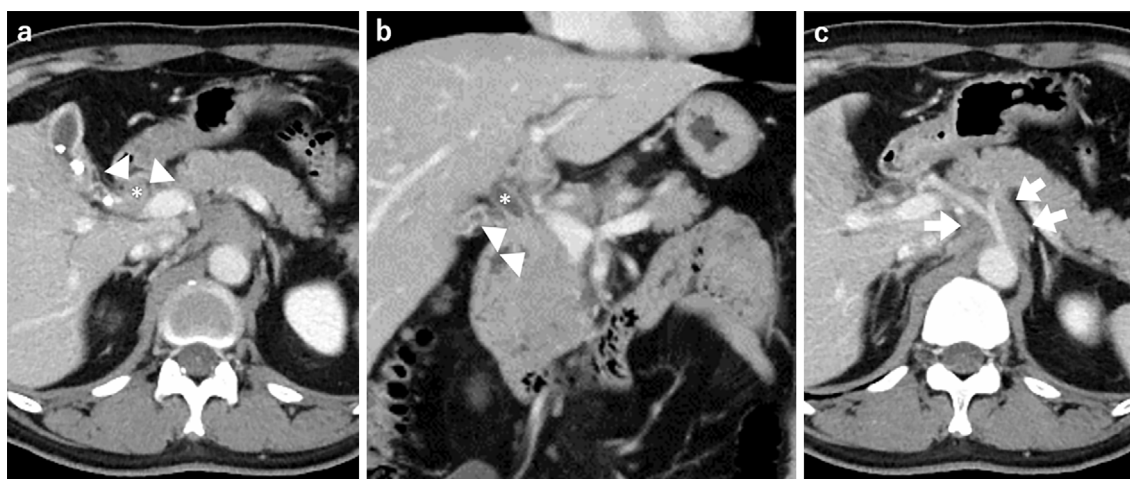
Contrast-enhanced CT (CE-CT) of the abdomen (July, 20XX). (a) Axial, (b) coronal; CE-CT confirmed circumferential wall thickening and stenosis in the common bile duct (*) with a contrast effect. (c) Axial CE-CT confirmed a soft tissue mass around the celiac artery (arrow).
